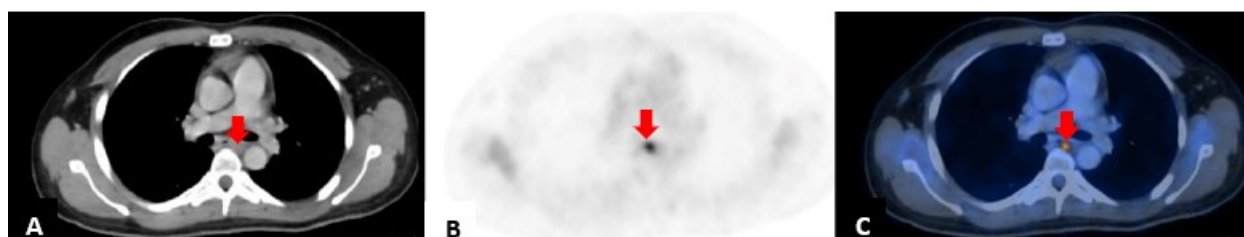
Axial view showing the (A) CT, (B) PET, and (C) fused PET/CT images of the patient's initial PET/CT scan showing the enlarged mediastinal lymph nodes that extends into the retrocrural space (red arrows) .
